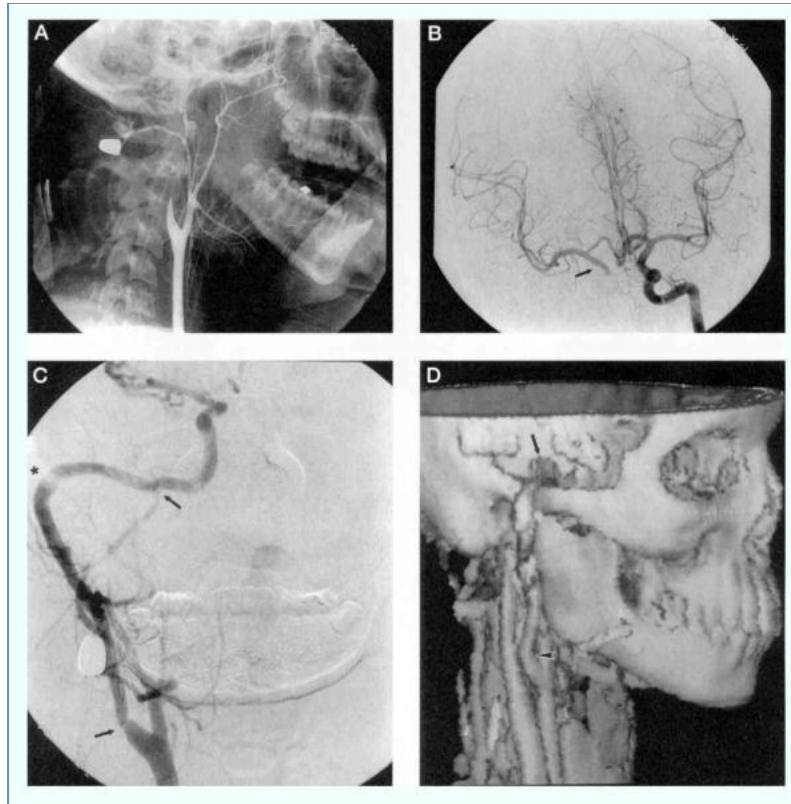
Case 1: (A) A right lateral carotid angiogram demonstrating a complete ICA occlusion. (B) Anteroposterior cerebral angiogram showing collateral circulation from the left ICA to the right ACA and MCA through the circle of Willis. Reflux down the right ICA (arrow) suggests that the petrous portion of the ICA will be patent and suitable for the distal anastomosis. (C) Postoperative angiogram after proximal anastomosis revision showing sites of anastomoses (arrows) and patent graft coursing over the zygoma (*). (D) Postoperative three-dimensional CT angiographic reconstruction showing the site of proximal anastomosis (arrowhead) and small temporal craniotomy (arrow).
